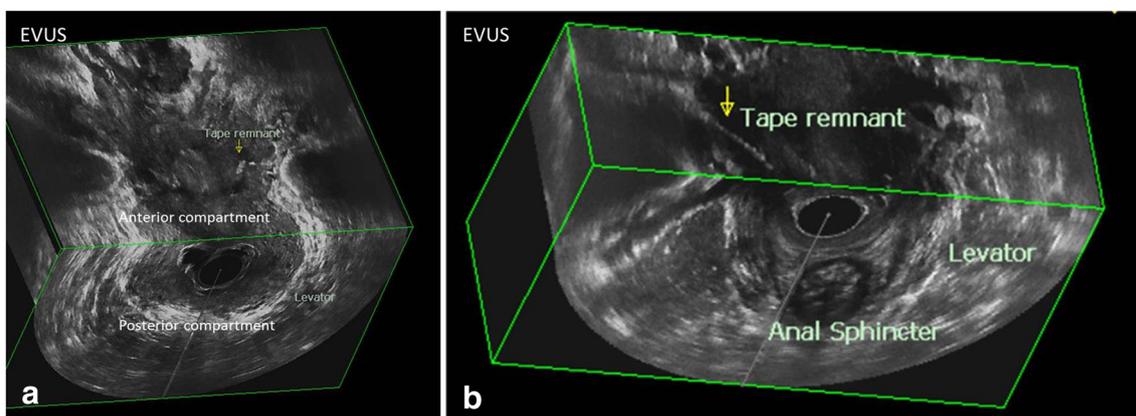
Localising MUS mesh remnants. a Endovaginal ultrasound demonstrating a small segment of mesh localised on the left as labelled. There is also a hyperechoic shadow on the right, which represents scar tissue. The patient was unsure if she had had all her mesh removed, but
